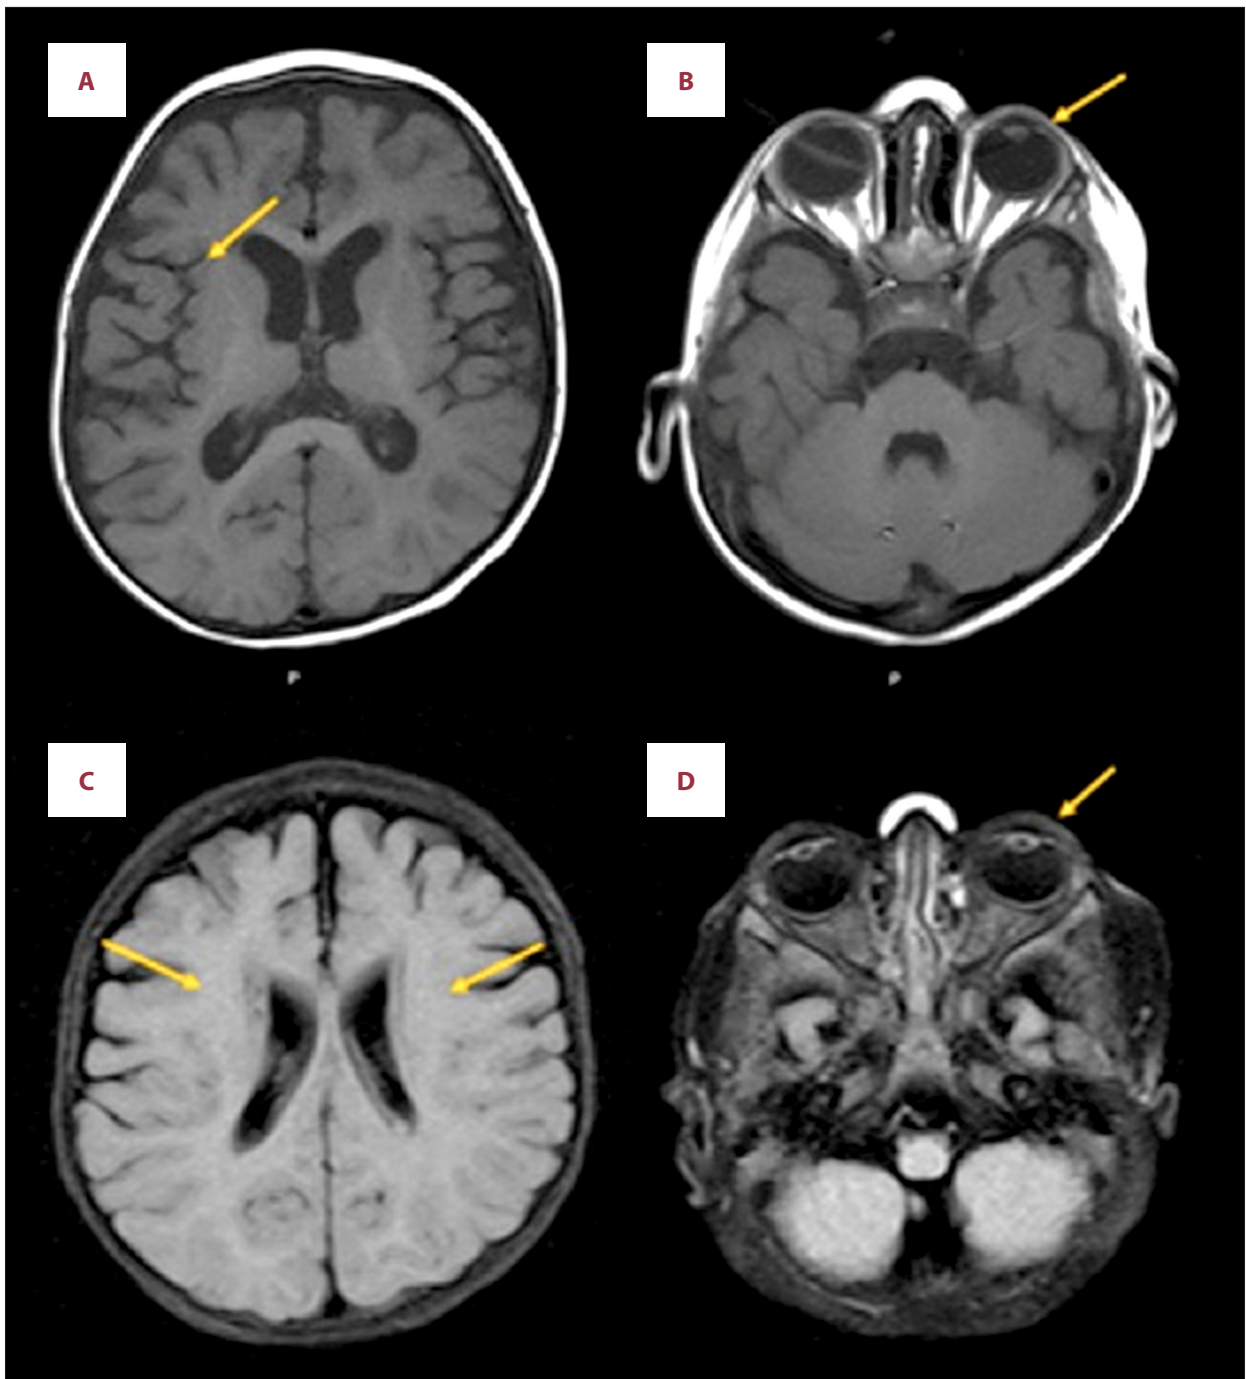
MRI brain; (A) Reveals moderate cerebral atrophy, the ventricular dilatation is proportionate to the amount of cortical atrophy. (B) Prominent optic nerve on the right side as a sign of stretching, most likely due to the severe congenital glaucoma of the same side. (C) There is no basal ganglia calcification on MRI, which is unusual in AGS. (D) Increased corneal thickness is appreciated more on the right side.
